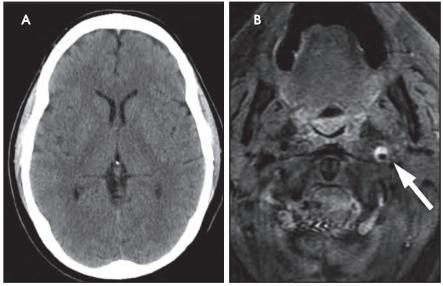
55-year-old man with 3 weeks of headache, initially treated for sinusitis without improvement. He subsequently developed blurred vision and on exam was found to have Horner syndrome. (A) Unenhanced axial CT image is normal. (B) Axial T1-weighted image with fat suppression through the neck shows crescent-shaped hyperintense signal in the wall of the left internal carotid artery (arrow) with associated luminal narrowing due to carotid dissection.
